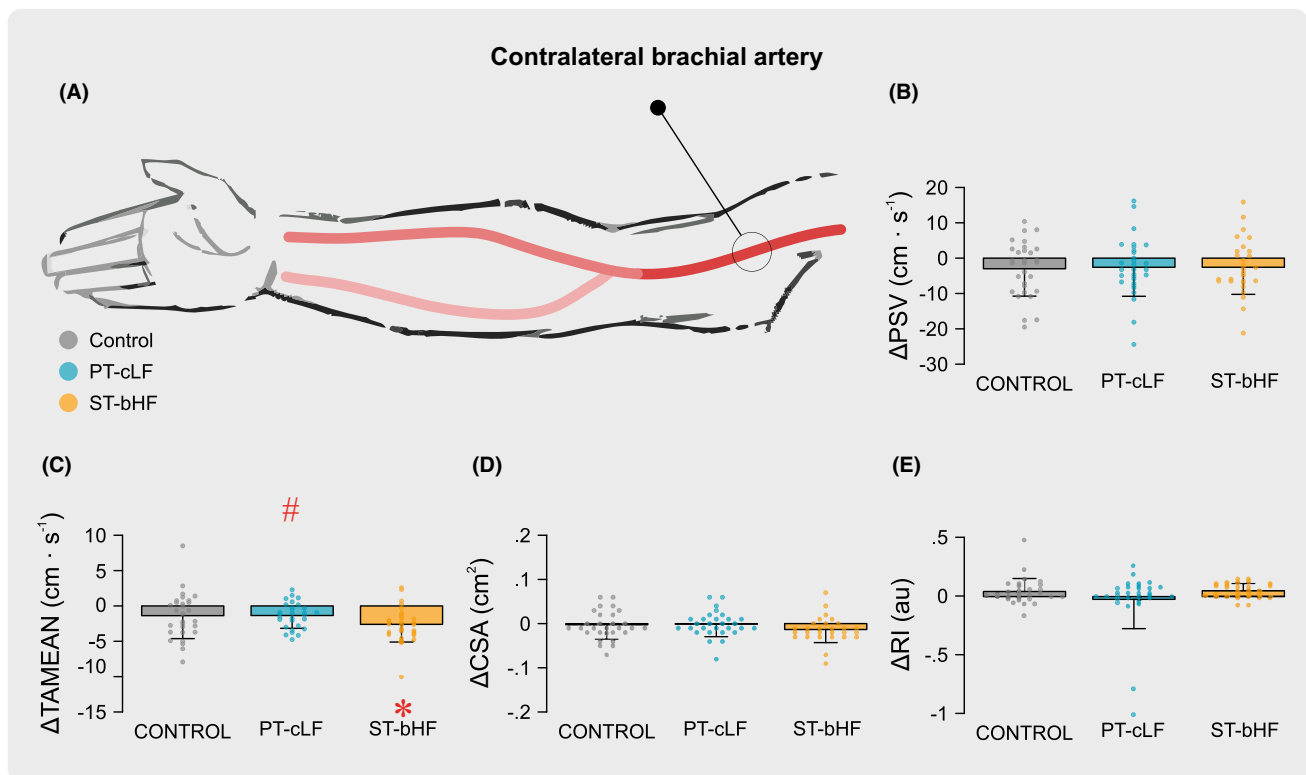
Effects of median nerve pPNS on contralateral arm blood flow. (A) Doppler US was measured at the contralateral brachial artery exclusively. (B) Mean difference of peak systolic velocity (PSV). (C) Mean difference of time-averaged medium velocity (TAMEAN). (D) Mean difference of cross-sectional area (CSA). (E) Mean difference of resistance index (RI). All bars represent posttreatment mean difference \pm SD. #, in red, in the upper part of the figure denotes statistical significance on the secondary analysis (ANCOVA generalized model) and the *, in red, has been used to represent the *post hoc* comparisons.
